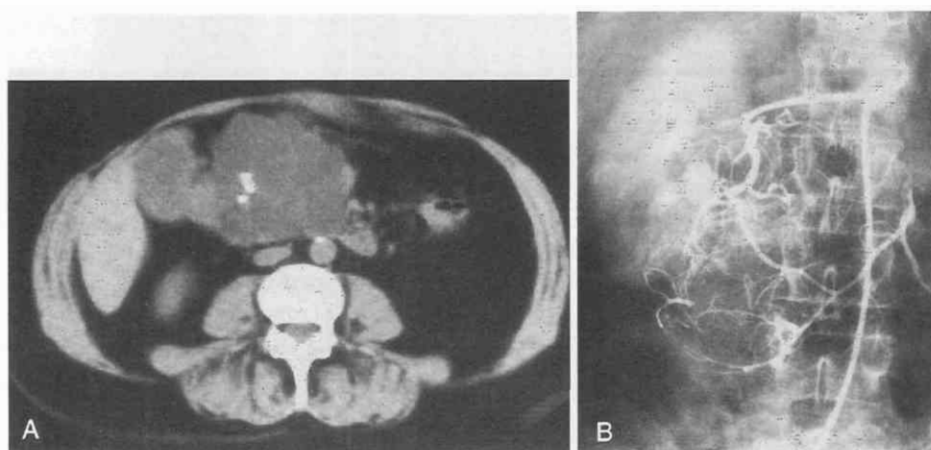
Microcystic adenoma. *A*, Plain CT scan. Large, lobulated cystic mass with foci of central calcifications. *B*, Selective angiography. Enlarged pancreatic feeding arteries from the gastroduodenal artery. (From Mathieu D, Guigui B, Valette PJ, et al: Pancreatic cystic neoplasms. *Radiol Clin North Am* 27:163-176, 1989.)
